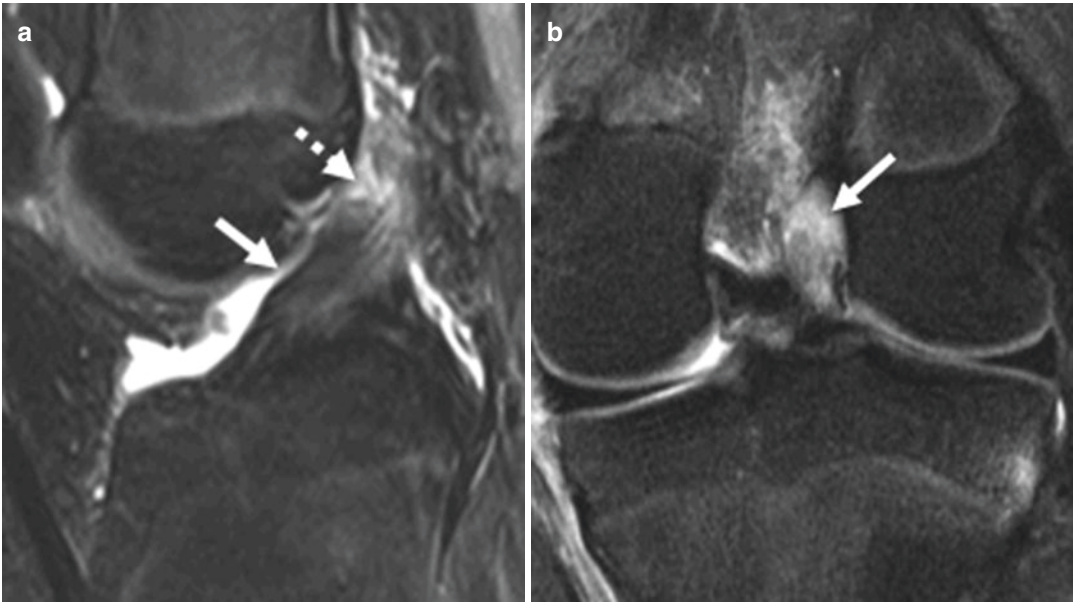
(a) Sagittal T2-weighted fat-suppressed image in the a 14-year-old boy demonstrates a normally oriented ACL with preservation of the black stripe anteriorly (*arrow*); however, there is abnormal hyperintense signal at the proximal ligament (*dashed arrow*) that on this one view may be misinterpreted as a partial thickness tear. (b)
